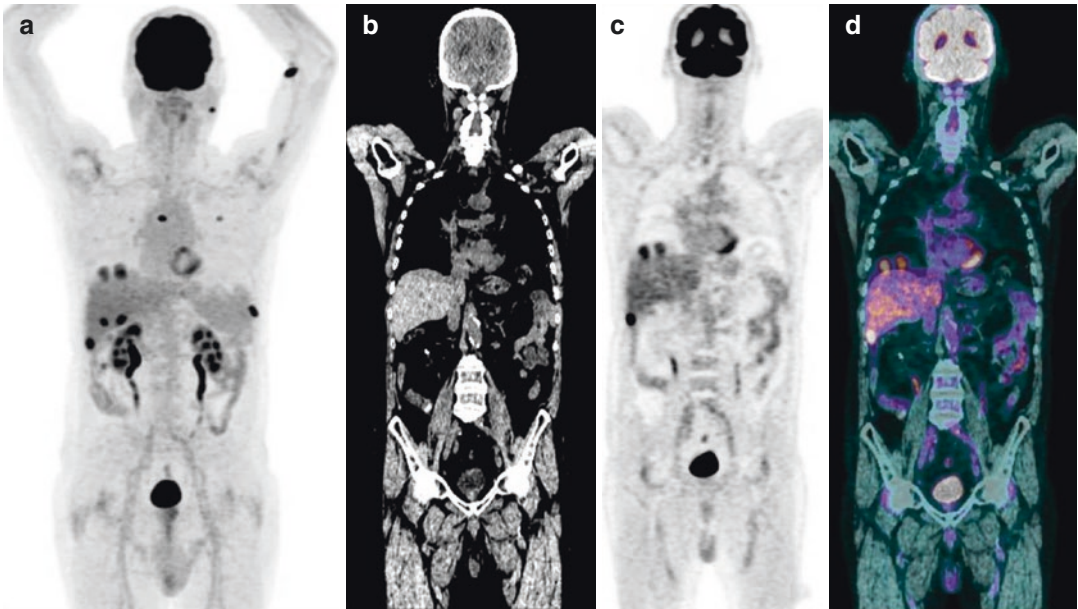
Patient with several metastases of colon cancer, evident in ^{18}F -FDG PET maximum intensity projection (a). As motion artifacts due to respiration during the PET acquisition, hepatic ^{18}F -FDG-avid lesions are not
